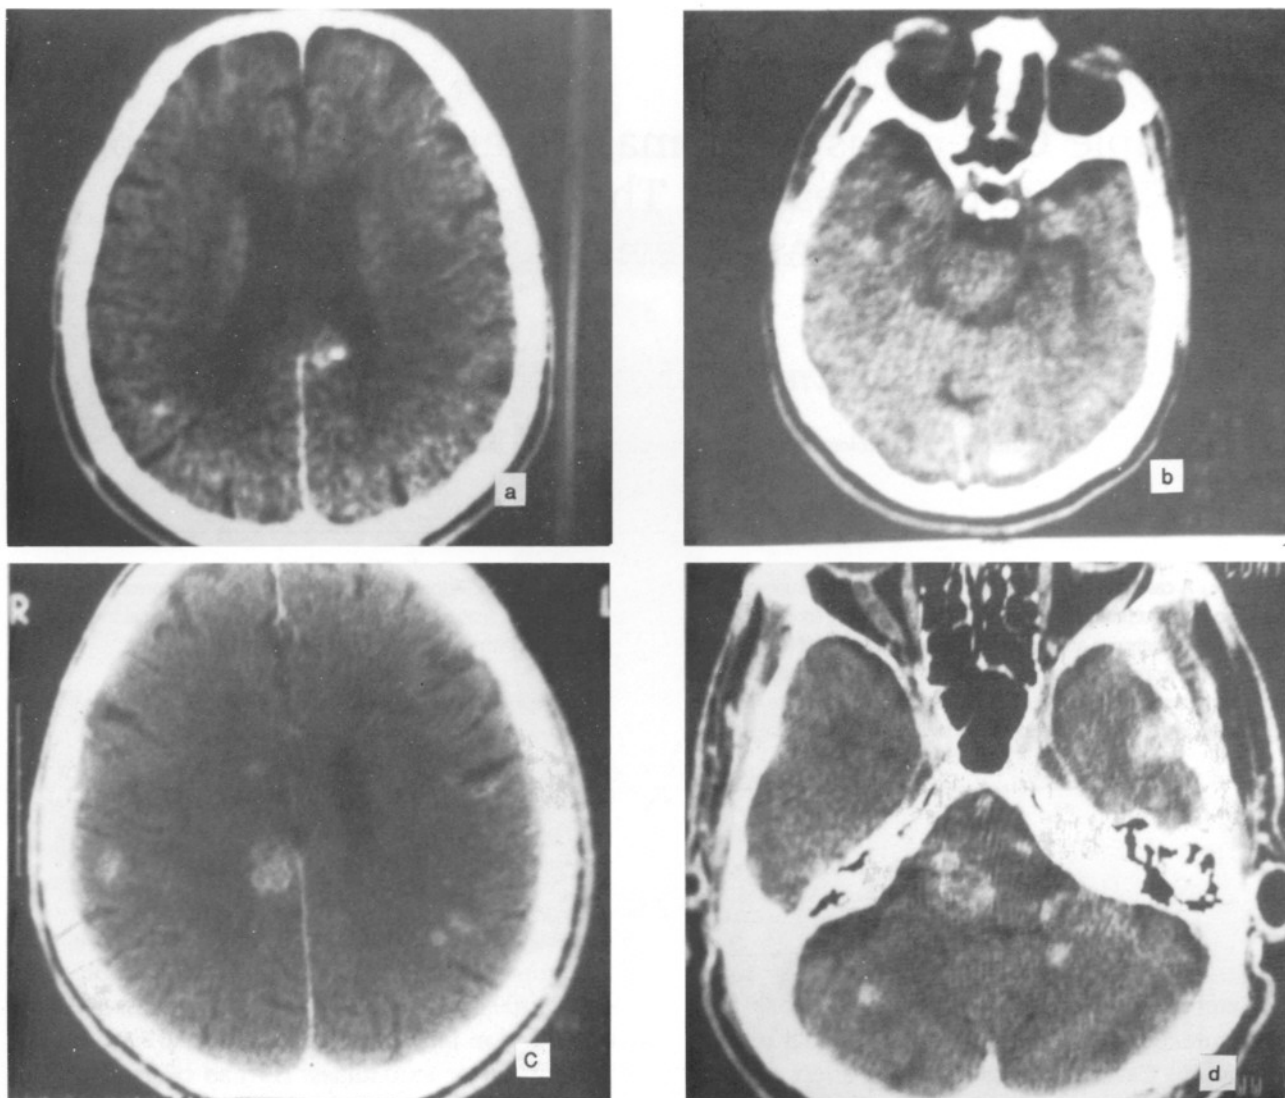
Computed tomography scans in 1984 (a,b) and in 1990 (c,d) showed multiple hyperdense lesions with numerous coarse punctate calcifications, no mass effect and no surrounding edema. There was slight enhancement after contrast administration.
